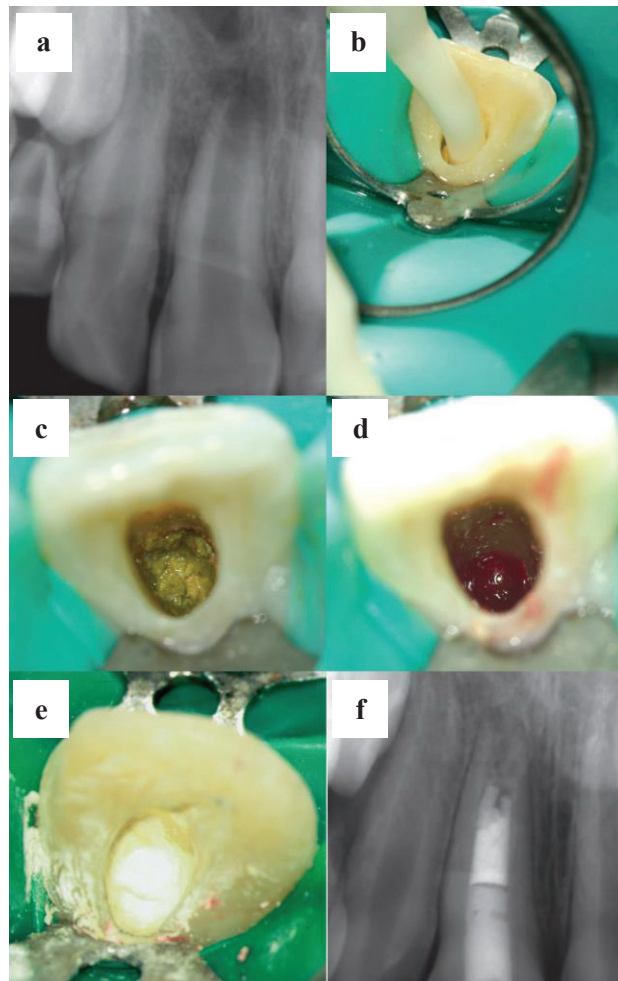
Etapes de la revascularisation endodontique. (a) Radiographie préopératoire d'une incisive centrale immature (11) dont la pulpe est nécrosée et qui présente une lésion apicale. (b) Mise en place d'une pâte contenant les trois antibiotiques. (c) Vue clinique de la médication dans le canal. (d) Vue clinique du canal rempli de sang. (e) Vue clinique du bouchon de MTA® (Mineral trioxide aggregate®) placé au contact du caillot sanguin. (f) Radiographie de contrôle à 10 mois postopératoire. (Simon 2010)
